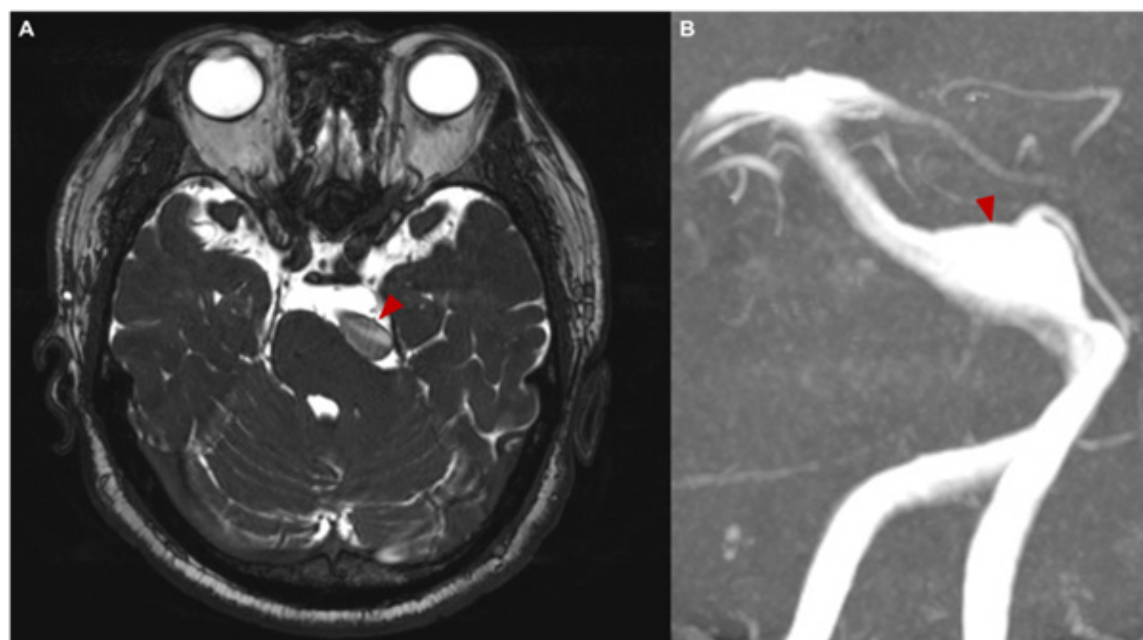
Brain MRI was performed before the operation. A) In the axial view of the CISS series, the dilated and tortuous BA was seen displacing the trigeminal root entry zone laterally. B) Three-dimensional magnetic resonance angiography of the BA in the coronal view revealed a left lateral deviation. (MRI = magnetic resonance imaging; CISS = constructive interference in steady state; BA = basilar artery).
